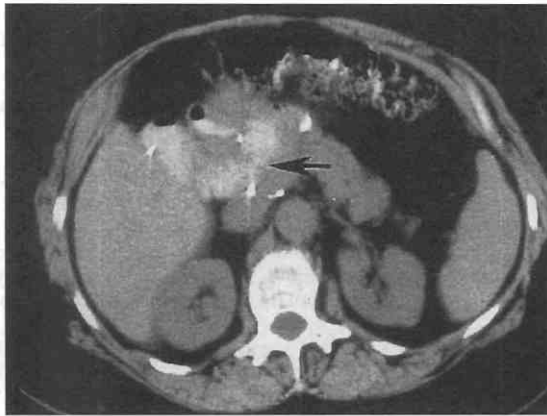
CT scan of postoperative pancreas shows dilute barium in bowel adjacent to the pancreas (arrow).
